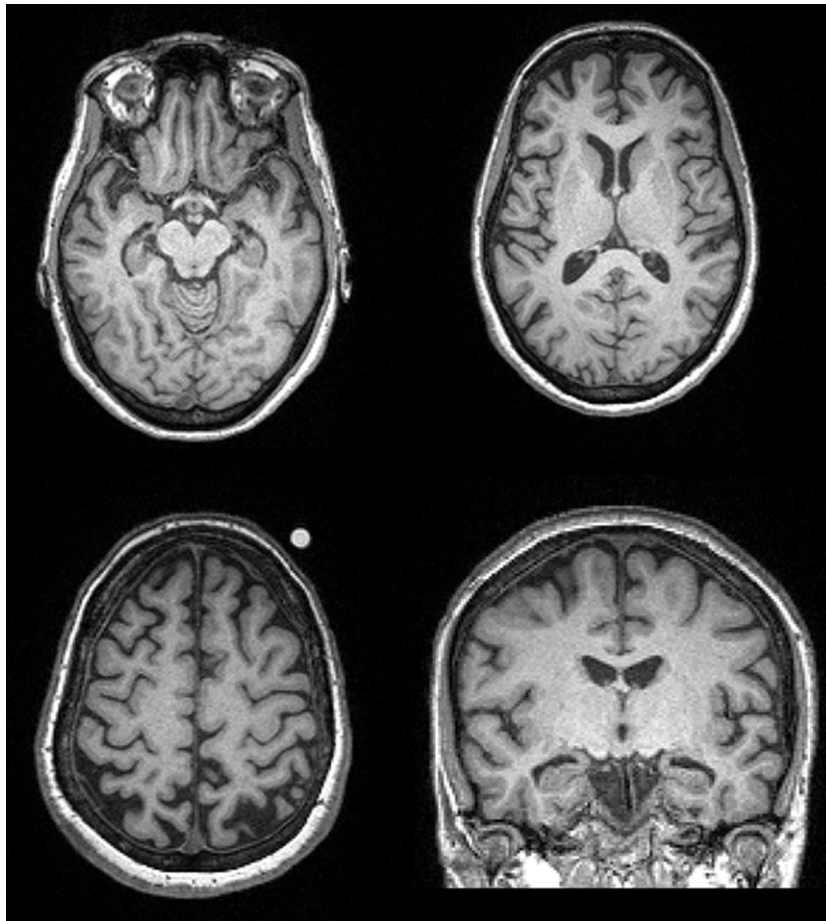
3 T MRI (T1 3D) showing moderate bilateral temporal and parietal atrophy.
